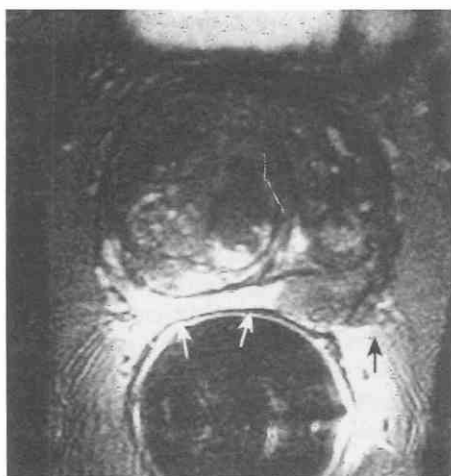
Invasion of the neurovascular bundle by prostate carcinoma. Axial T2-weighted fast spin-echo image (TR = 5000 msec, TE_{eff} = 140 msec) shows normal high-signal intensity to the right peripheral zone (white arrows). A low-signal-intensity mass in the left posterolateral peripheral zone invades the left neurovascular bundle (black arrow) and invades through the capsule on the left side. The central gland is markedly enlarged and has the typical appearance of benign prostatic hyperplasia. TE_{eff}, effective echo time.
